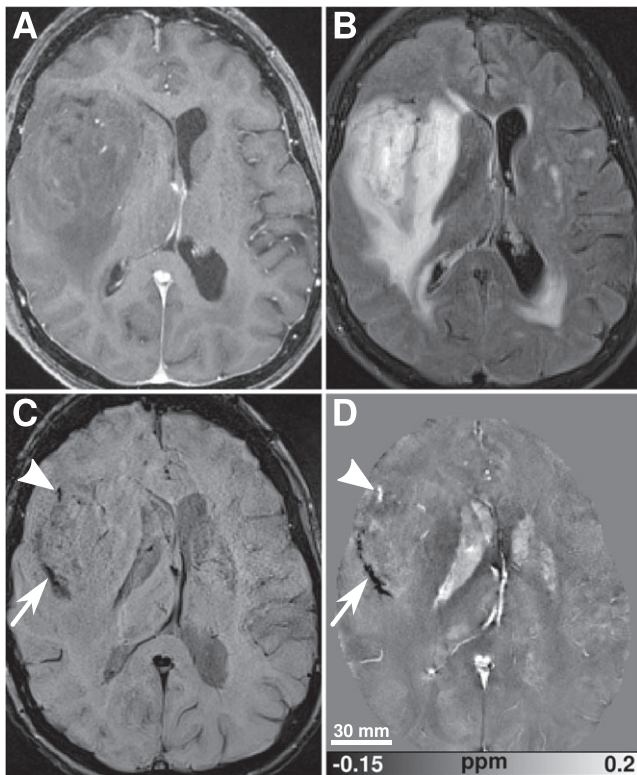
Seventy-four-year-old patient with a right temporal oligodendroglioma. (A) Contrast-enhanced T_1 -weighted image. (B) T_2 -weighted fluid-attenuated inversion recovery (FLAIR) image. (C) Susceptibility-weighted image. (D) Quantitative susceptibility map. Substantial intratumoral susceptibility variations (arrowhead, arrow) are clearly seen with susceptibility-weighted imaging (SWI) and quantitative susceptibility mapping (QSM). Interestingly, these variations show no correlates on the conventional T_1 -weighted and T_2 -weighted FLAIR images. QSM clearly suggests that these susceptibility variations are likely produced by calcium deposits (arrow) and blood products (arrowhead). The MRI data were kindly provided by Alexander Radbruch (Department of Neuroradiology, University of Heidelberg Medical Center, Heidelberg, Germany).
